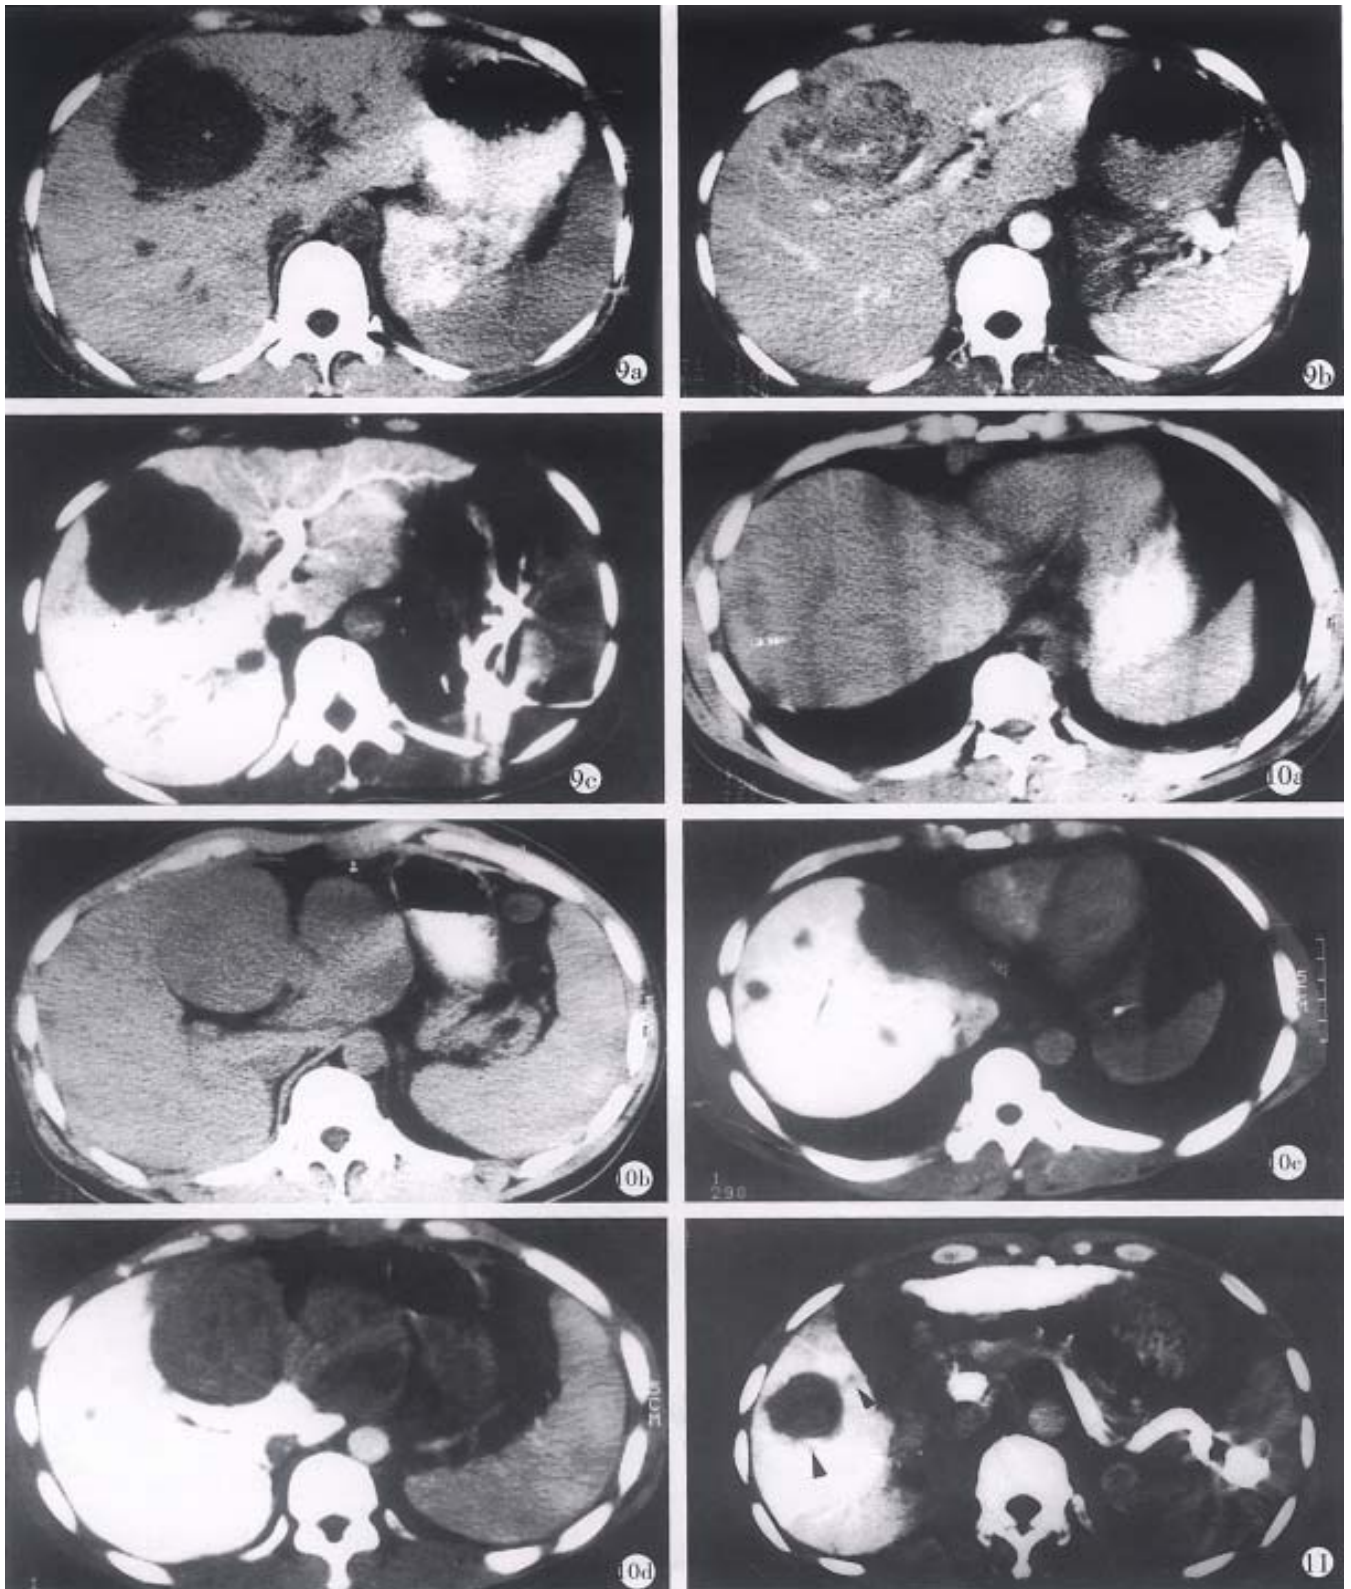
Primary hepatocyte carcinoma of a 30- year-old female patient. a. plain CT scan; b. enhanced CT; c. CTSP. Though they all could show carcinoma, CTSP not only could show it more clearly than the other two, but also show metastases to the right of the inferior vena cava.
